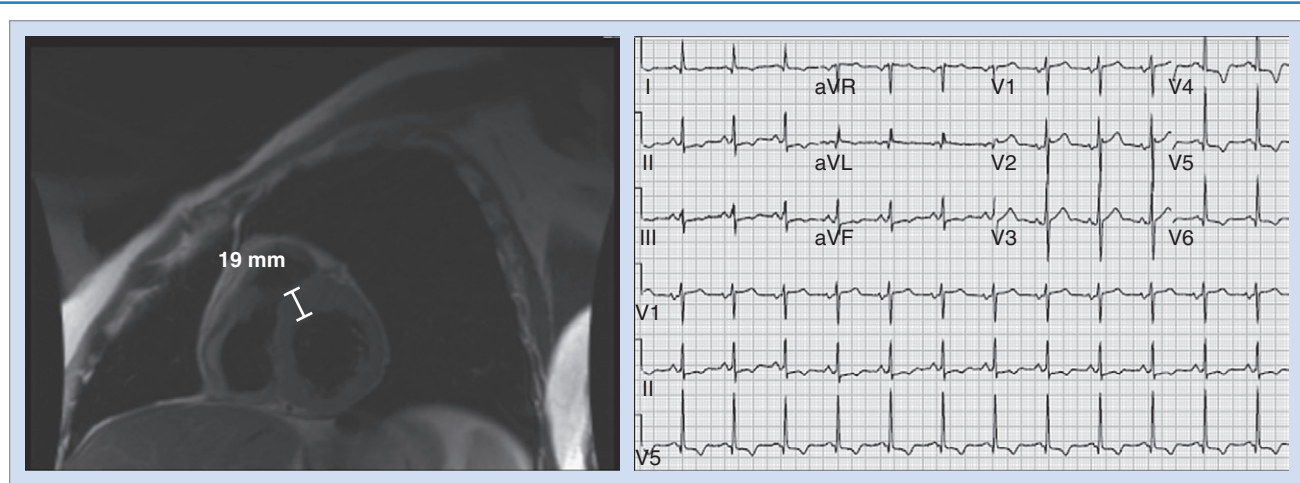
A middle-aged man with a known diagnosis of hypertrophic cardiomyopathy. Cardiac magnetic resonance imaging revealed asymmetric septal hypertrophy.
